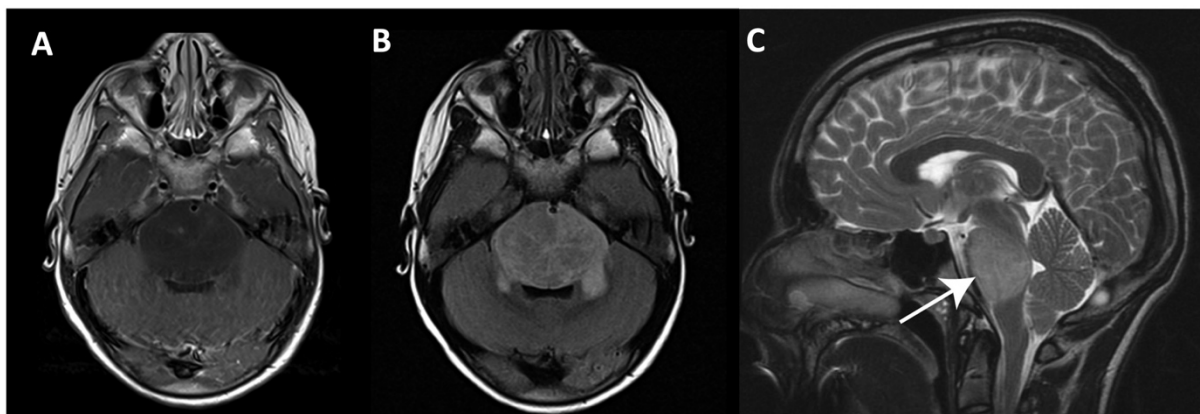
MRI Scans showing typical presentation of DIPG at diagnosis.
